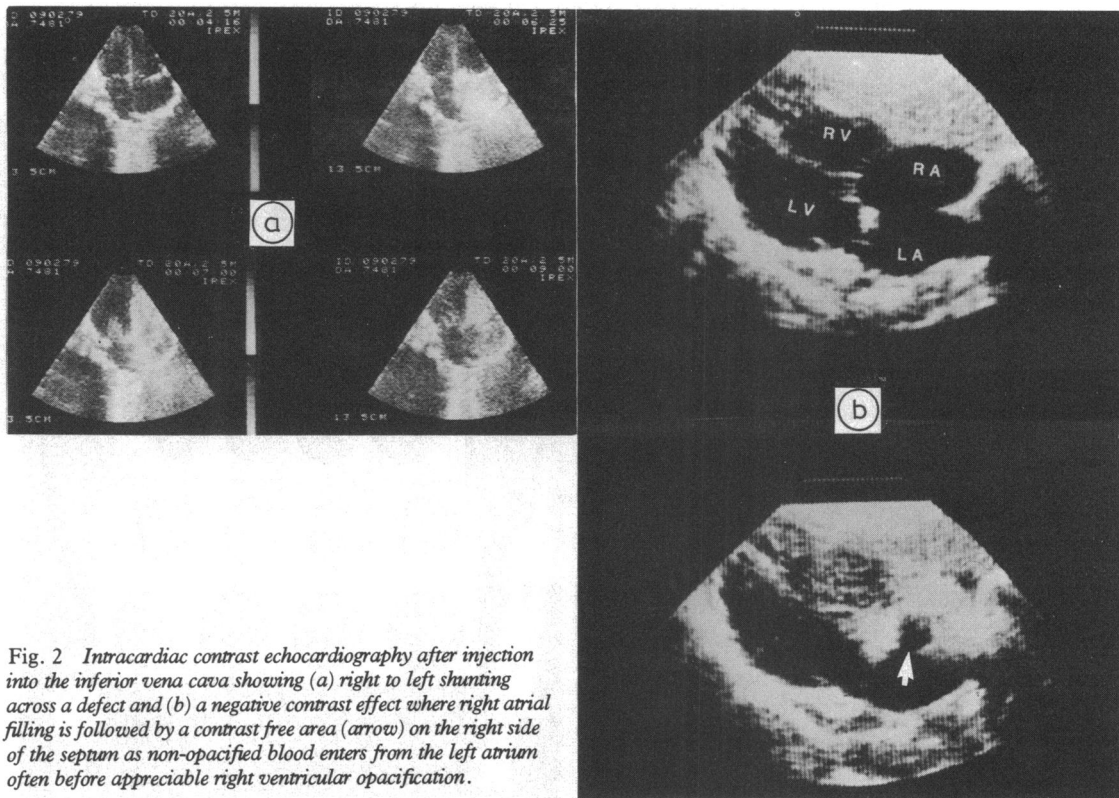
Intracardiac contrast echocardiography after injection into the inferior vena cava showing (a) right to left shunting across a defect and (b) a negative contrast effect where right atrial filling is followed by a contrast free area (arrow) on the right side of the septum as non-opacified blood enters from the left atrium often before appreciable right ventricular opacification.
